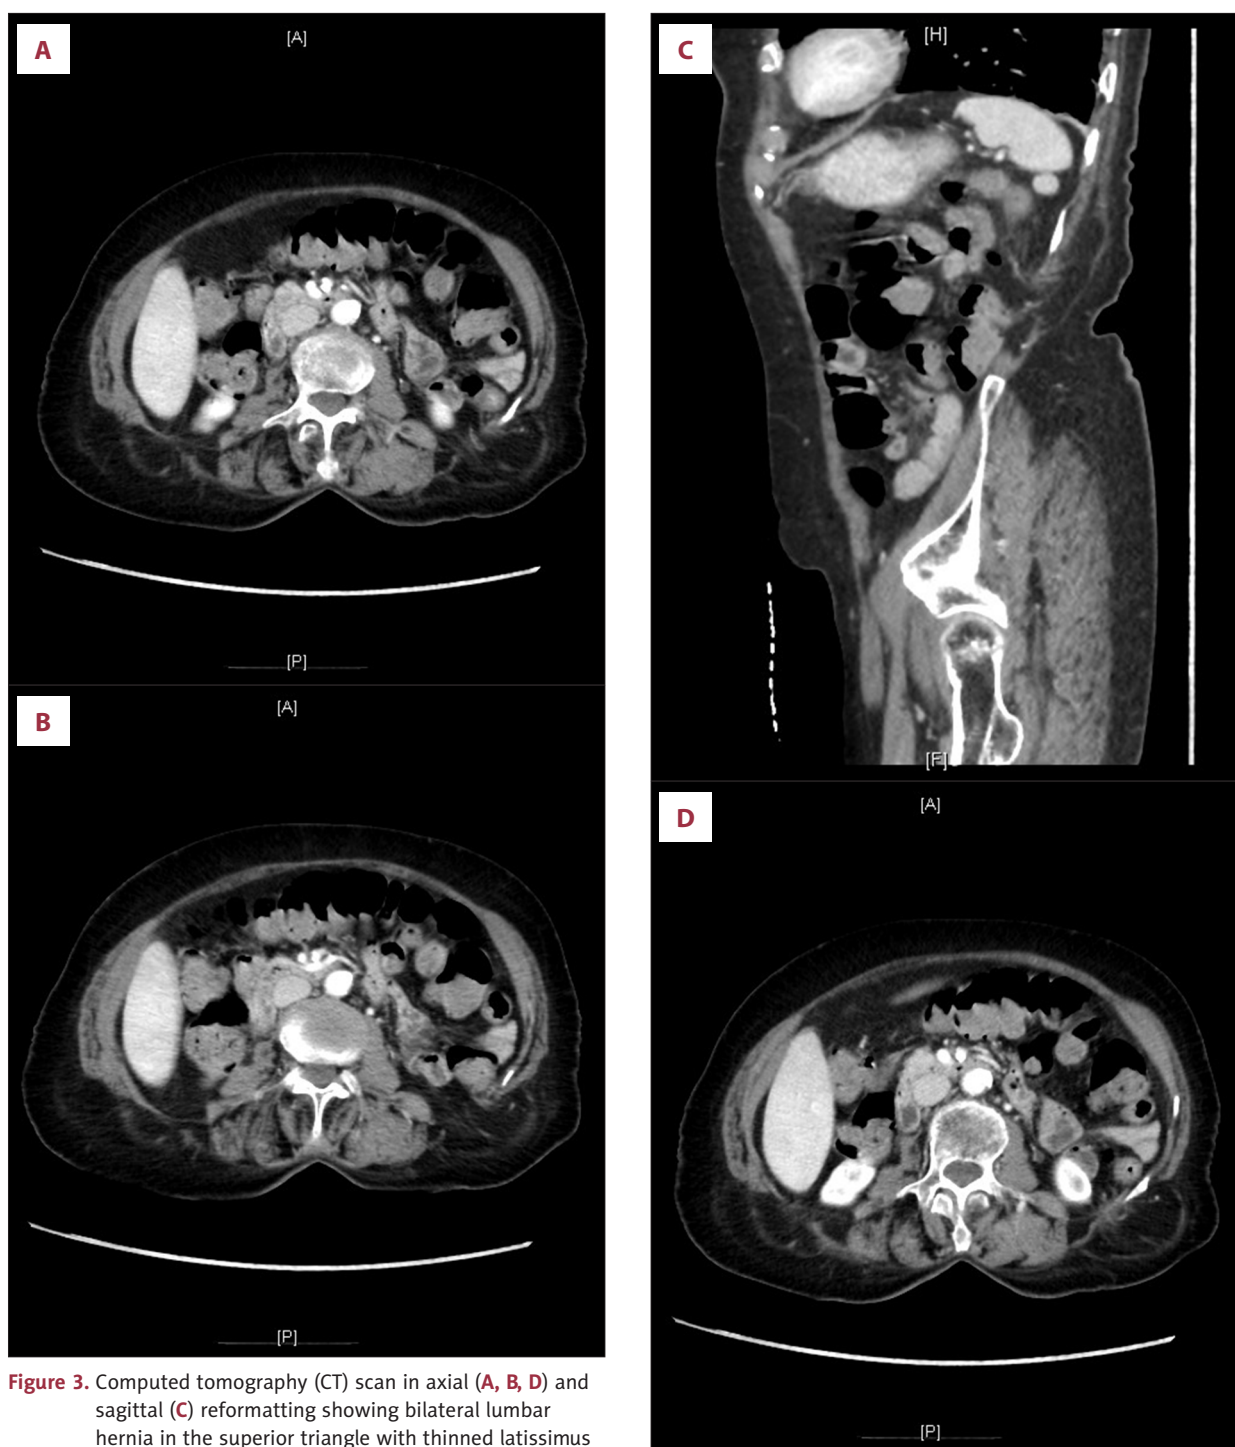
Computed tomography (CT) scan in axial (A, B, D) and sagittal (C) reformatting showing bilateral lumbar hernia in the superior triangle with thinned latissimus dorsi muscle and disrupted thoracolumbar fascia. Hernia sac contains extraperitoneal fat, with no bowel content in CT scan.
